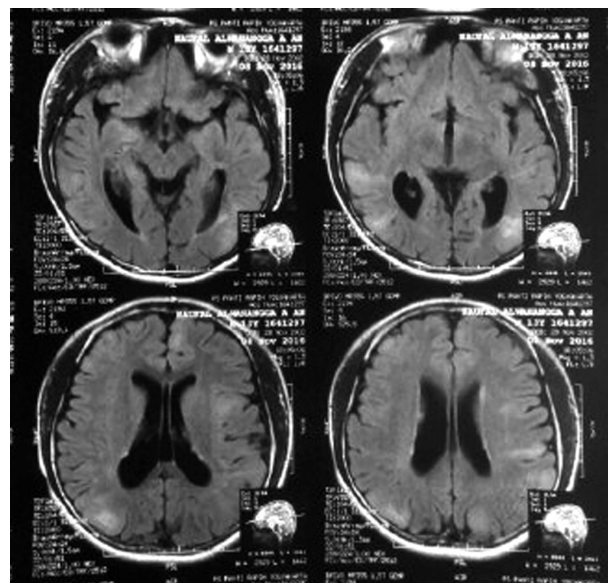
MRI showed some tubers in brain parenchyme (white circles) and sub-ependymal nodule at the wall of the lateral ventricle (red circle)
